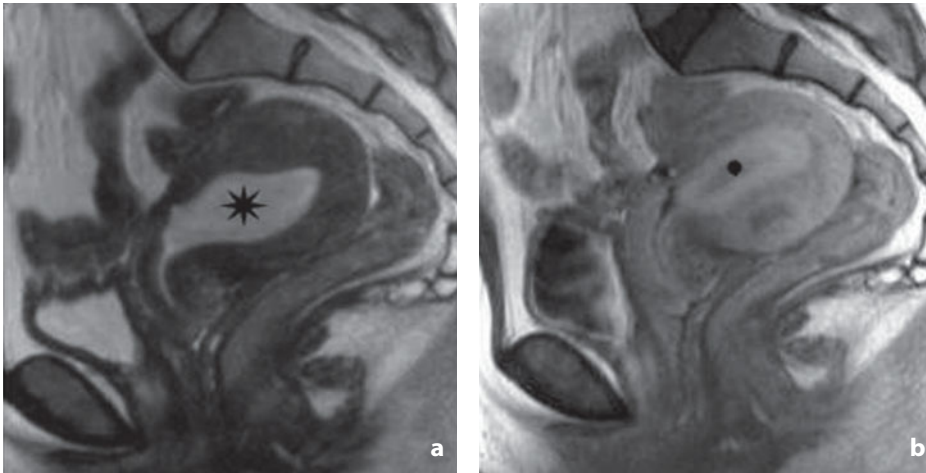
Magnetic resonance. Endometrial hyperplasia. Sagittal T2-weighted image (a) shows widening of the cavity (*asterisk*) due to thickening of the endometrium, which in the post-contrast T1-weighted sequence (b) appears enhanced with the exception of a central component consisting of secretion (*dot*)
